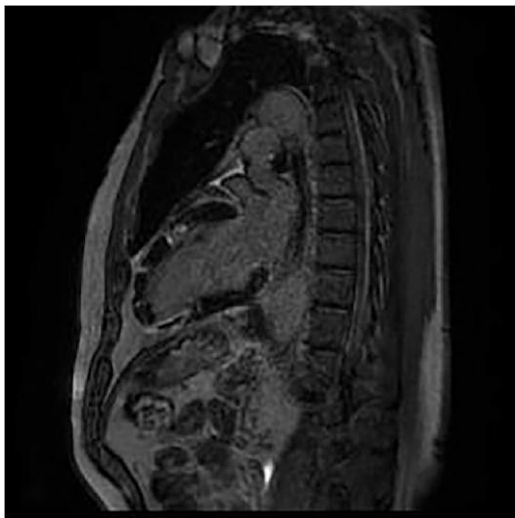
Magnetic resonance imaging in long axis view showing no reflux.
